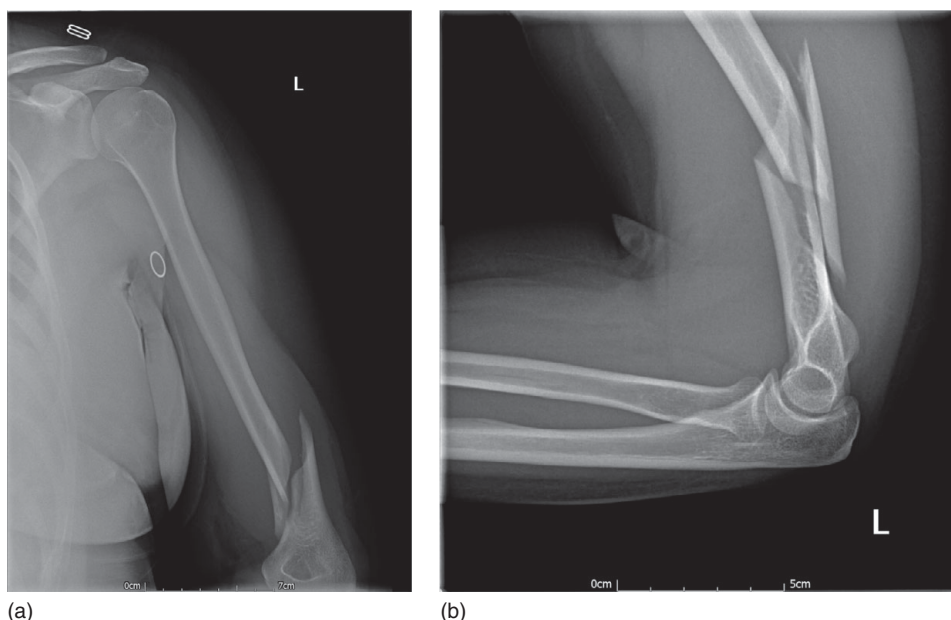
(a) Anteroposterior (AP) and (b) lateral radiographs left humerus
